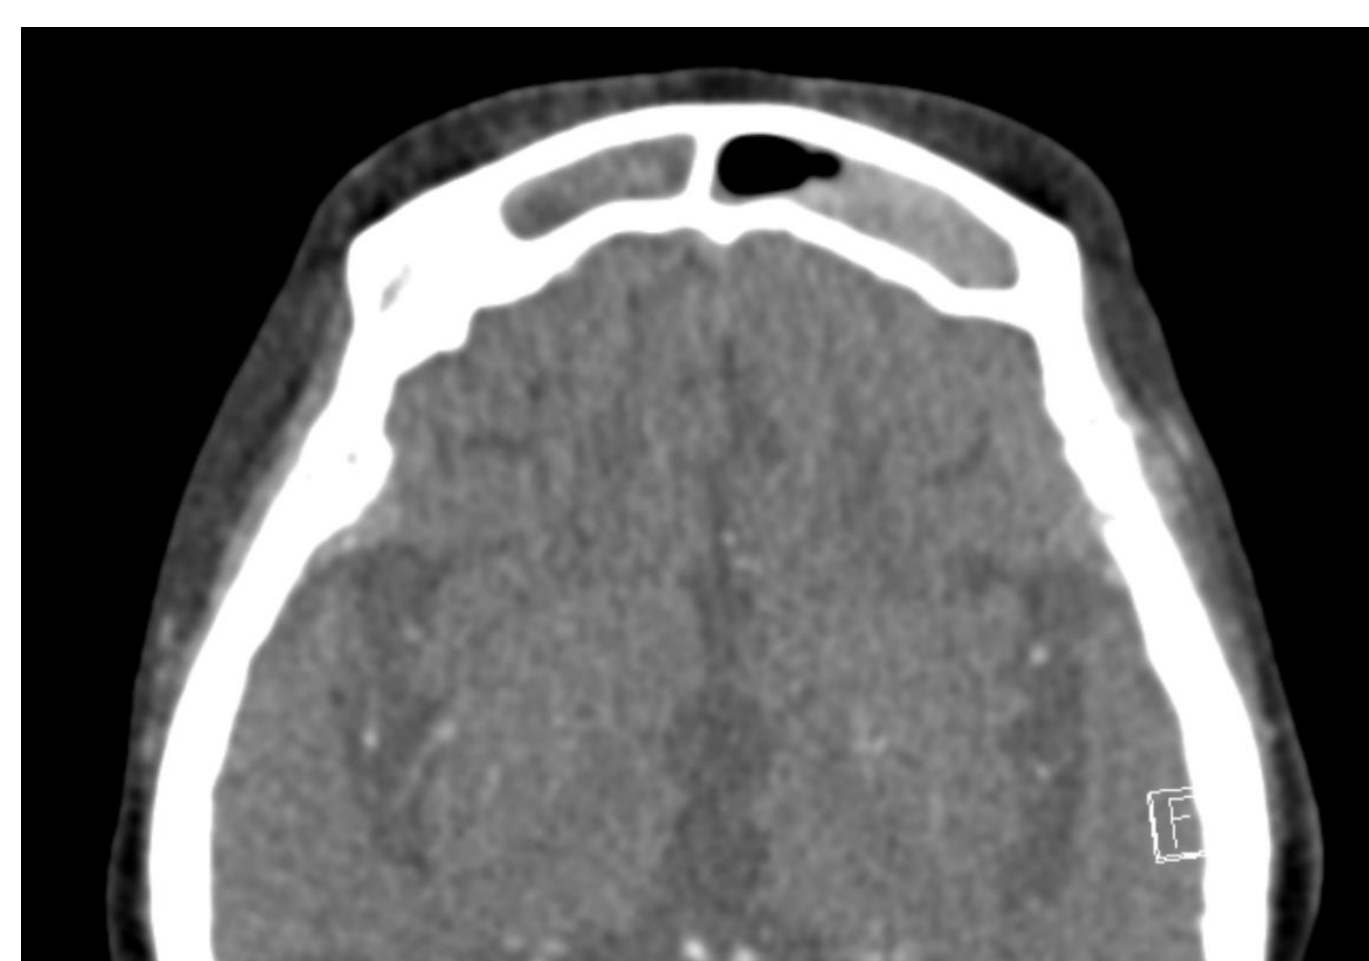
Frontal sinusitis on CT sinuses scan
